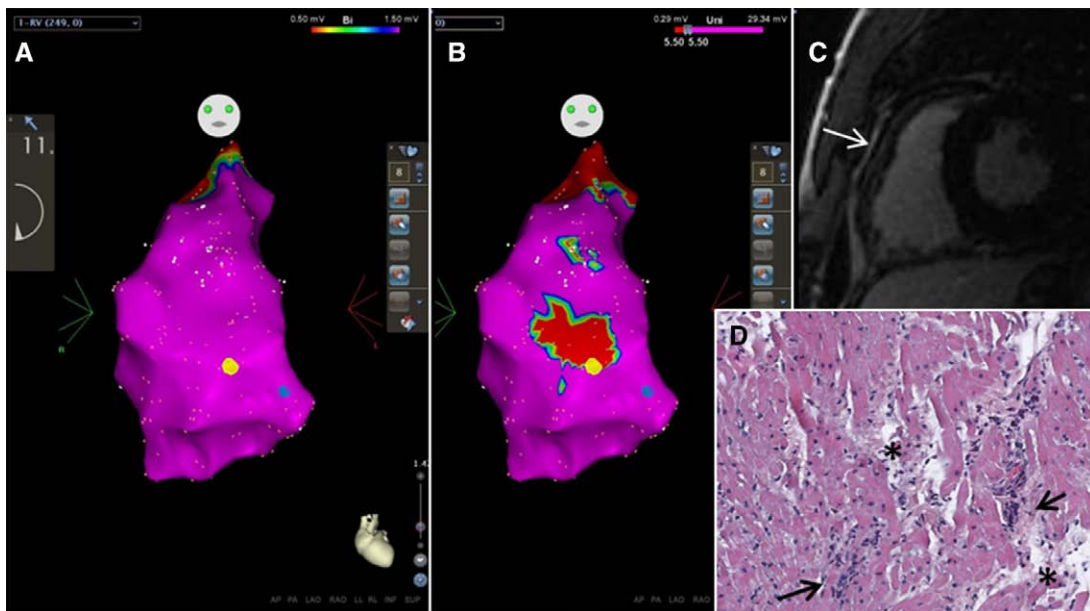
A and B, Bipolar (on the left) and unipolar (on the right) endocardial map of a patient with a biopsy diagnosis of active myocarditis. The yellow dot highlights the site of diagnostic biopsy sampling. The blue dot shows the site of normal biopsy sampling. C, Cardiac magnetic resonance imaging of the same patient. The arrow points out a subepicardial scar detected by delayed enhancement at the basis of the right ventricle outflow tract. D, Diffuse inflammatory infiltrates (arrows) associated with necrosis of adjacent myocytes (asterisks) consistent with the diagnosis of active myocarditis.
